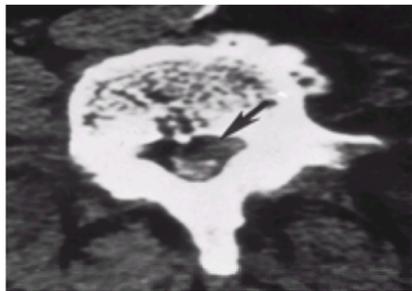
Axial computed tomography scan using intrathecal contrast agent showing that the dural sac is displaced posteriorly by a larger, herniated disk fragment (arrow). The patient had low back pain radiating to both legs, which was made worse by standing or walking.
